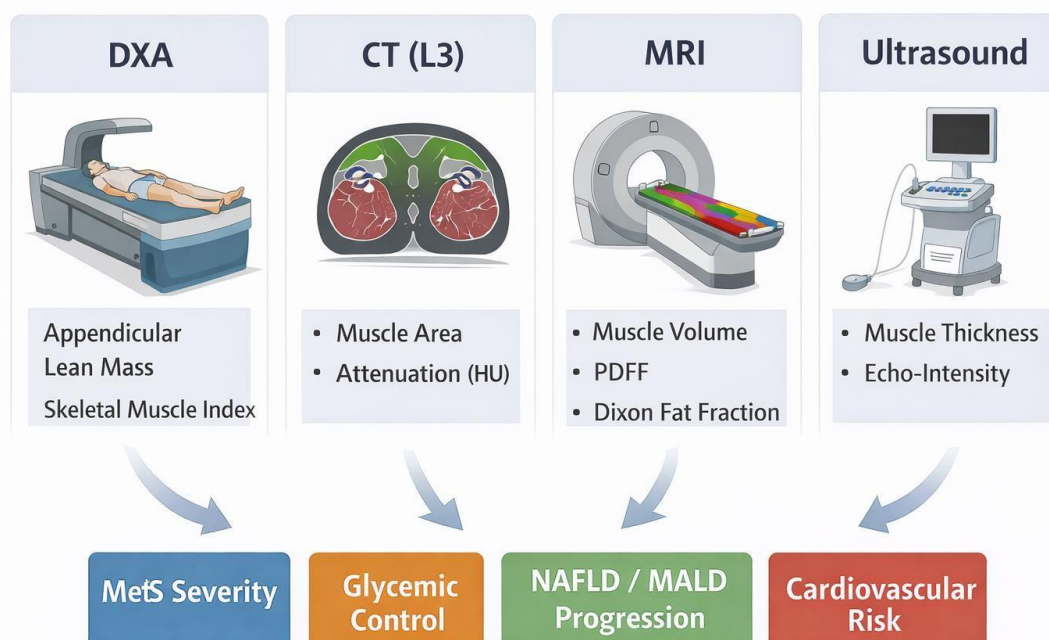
provides an overview of imaging-based techniques and quantitative biomarkers used for sarcopenia assessment in metabolic diseases, emphasizing the complementary roles of DXA, CT, MRI, and ultrasound in evaluating muscle quantity and quality
